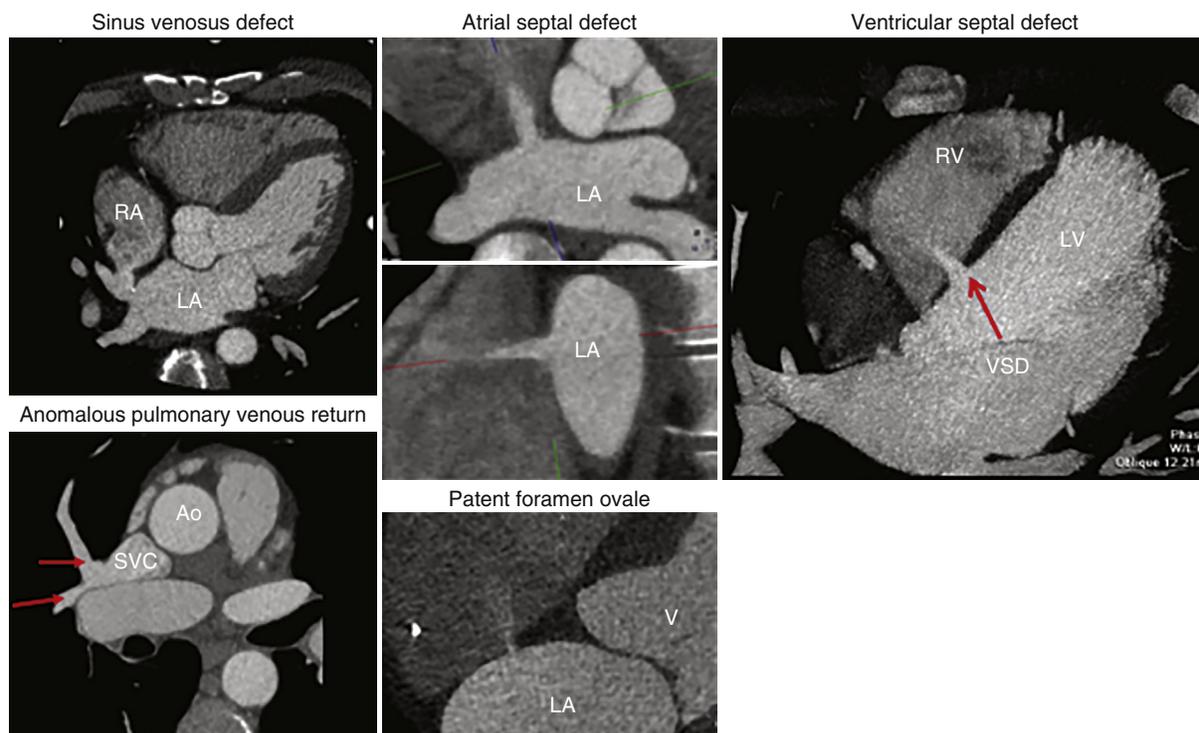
Examples of various intracardiac shunts on cardiac computed tomography. Ao, Aorta; LA, left atrium; RA, right atrium; SVC, superior vena cava; VSD, ventricular septal defect.
